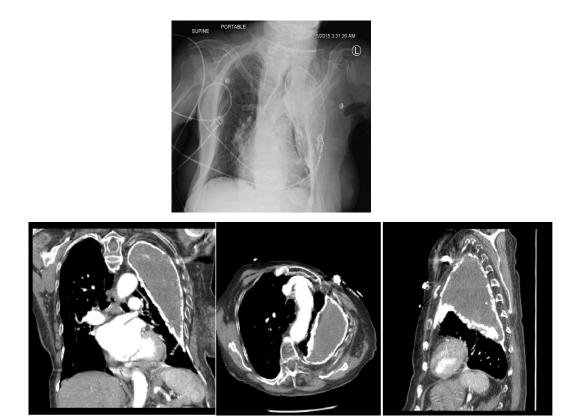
Chest radiograph showed a very large left-sided fluid collection surrounded by calcified pleura and collapse of the left lung. Figure 2: CT scan of chest with contrast revealed a chronic appearing increased density left pleural effusion contained within thick calcified pleura.
